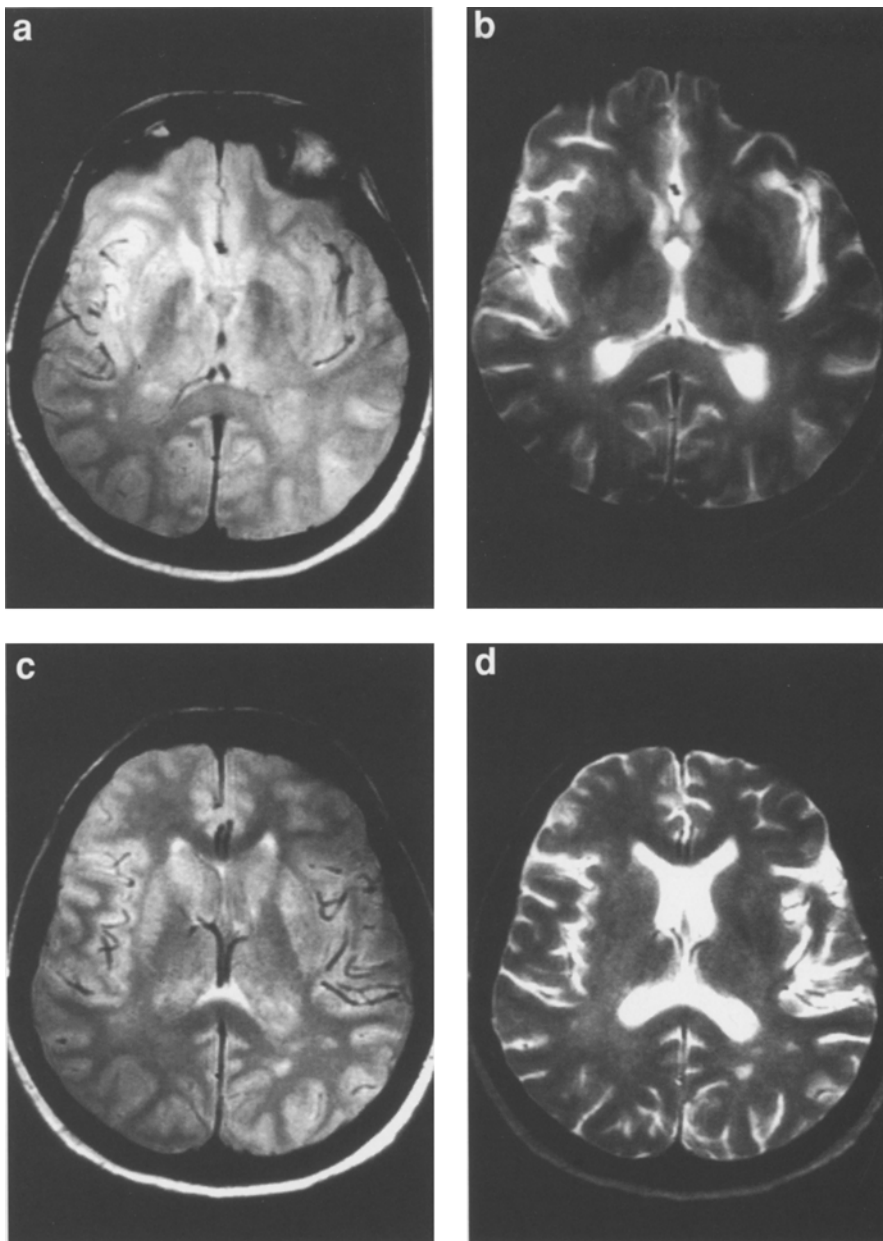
PD-weighted *a, c* and T2-weighted *b, d* axial MR images. Both sequences show small areas with an altered signal in the peritrigonal white matter on both sides, where there is also slight diffuse hyperintensity. There is a decreased signal in both putamens on the T2-weighted images
